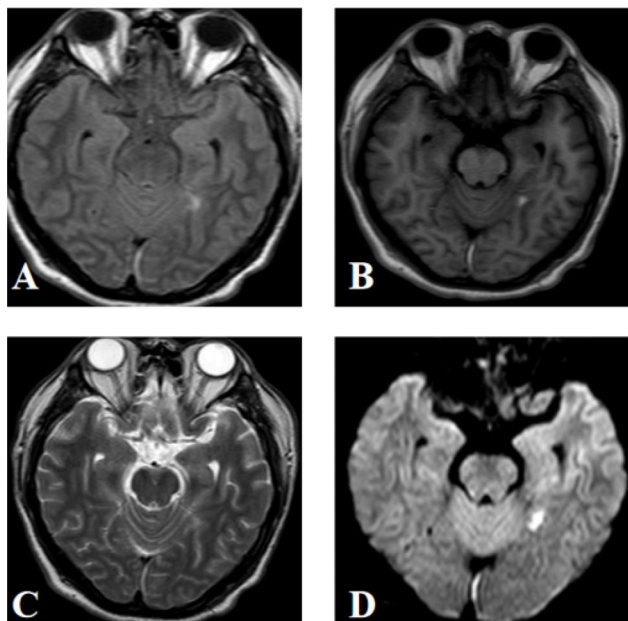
MRI scan showing deep patchy high-signal foci in the left temporal lobe. A T1-weighted images; B T1-weighted FLAIR images; C T2-weighted images; D diffusion-weighted images
